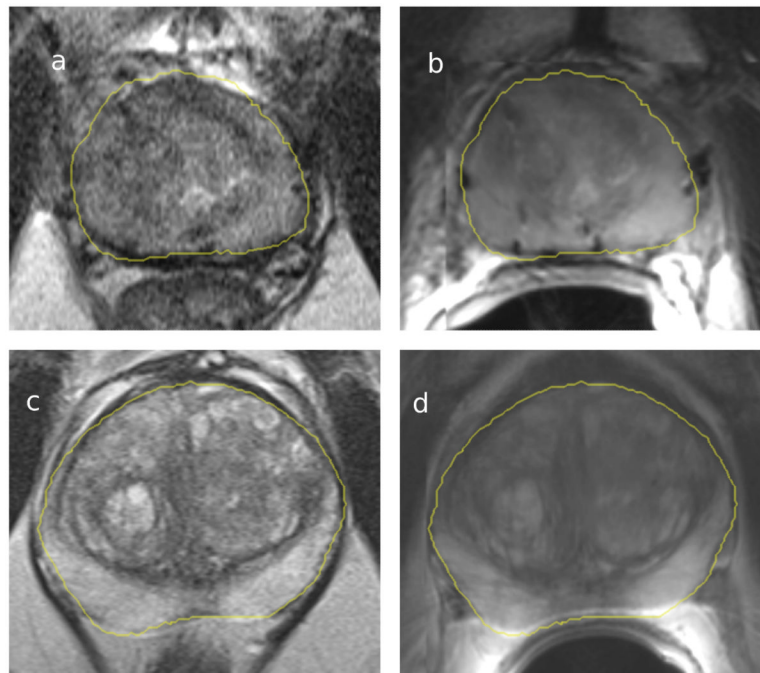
Registration results for patients 2 (top row) and 5 (bottom row). Images on the left (a and c) show an intra-procedural axial T2W image, images on the right (b and d) show the same slice of the registered pre-procedure T2W MRI. Yellow contour corresponds to the outline of the prostate gland segmented in the diagnostic image and warped to the intra-procedural image space by means of registration. Images for Patient 2 show brachytherapy seeds artifacts, as the patient previously underwent radiation therapy.
